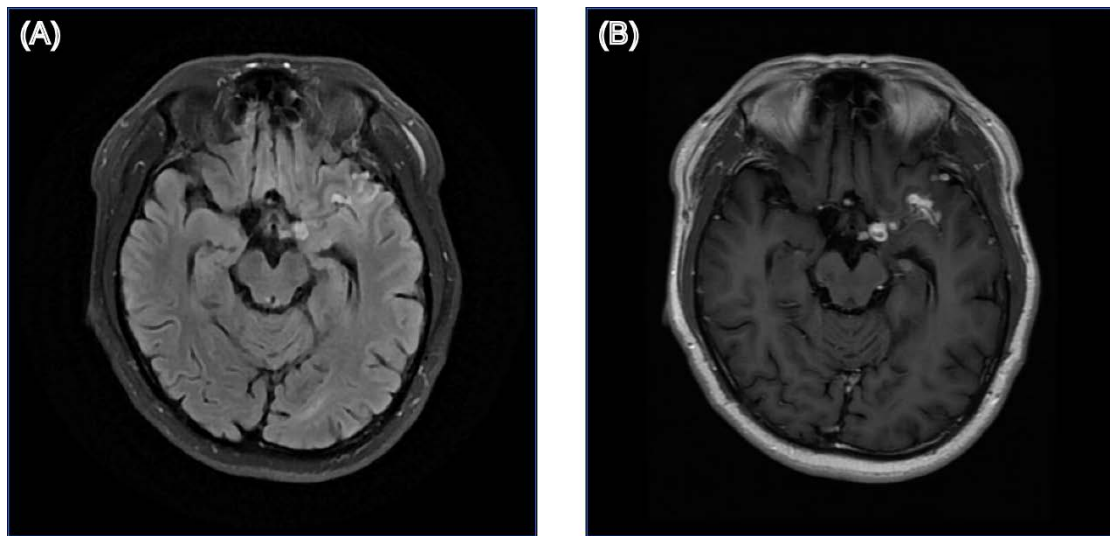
Structural brain MRI images of patient 07. (A) T2-weighted fluid-attenuated inversion recovery (T2-FLAIR) image; (B) Gadolinium-enhanced T1-weighted (Gd-T1w) image.
